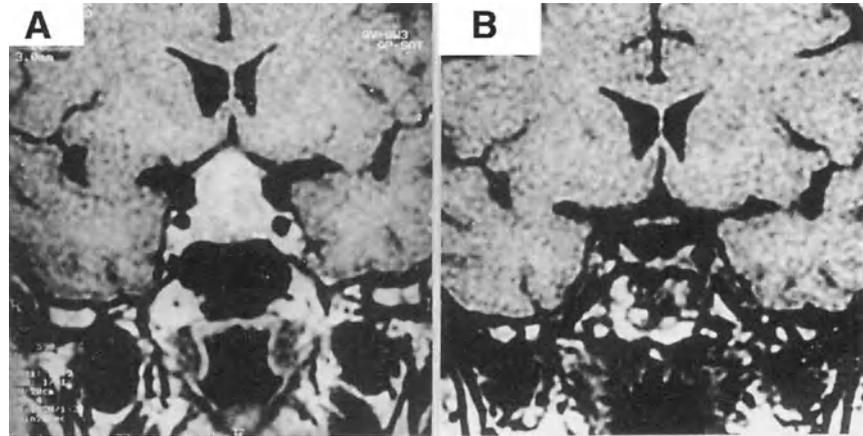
MRI (T1 weighted coronal views) of an acromegalic patient: (A) before and (B) after transsphenoidal surgery. Note the complete removal of tumor mass.
